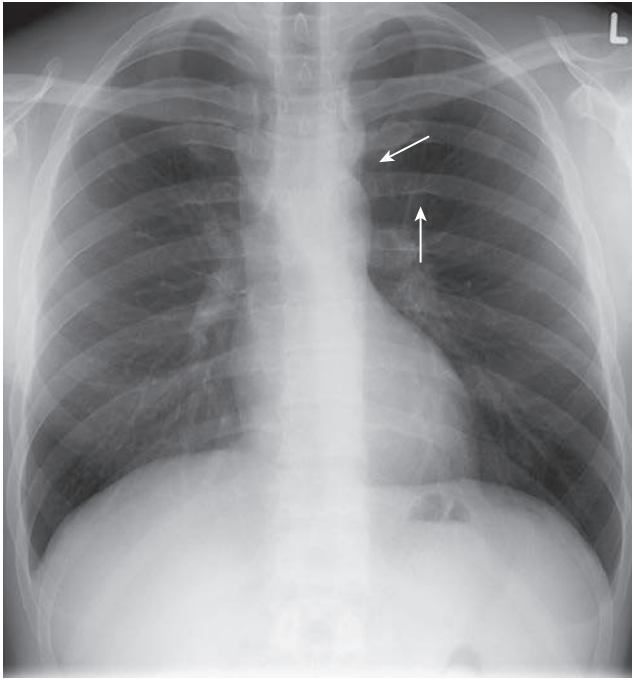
Chest radiograph of a 30-year-old man with native aortic coarctation showing the figure-3 sign (*diagonal arrow*), resulting from a prominent aortic knob, the stenotic segment, and the poststenotic aorta, as well as bilateral rib notching of the undersurface of upper ribs (*vertical arrow*).
